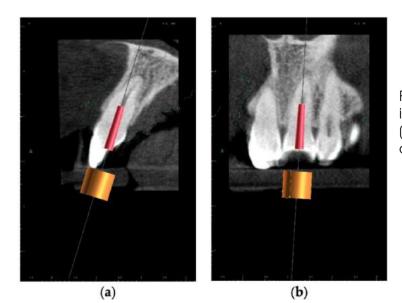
CBCT image presenting a scheduled virtual implant: endodontic access path in (a) sagittal view and (b) coronal view. The volume of the preserved dentin around the access path is shown.
